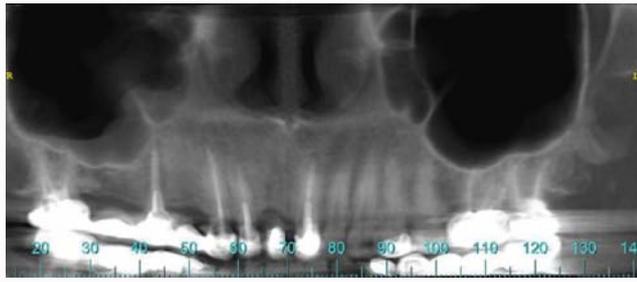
Preoperative cone beam computed tomography (CBCT) scan.
